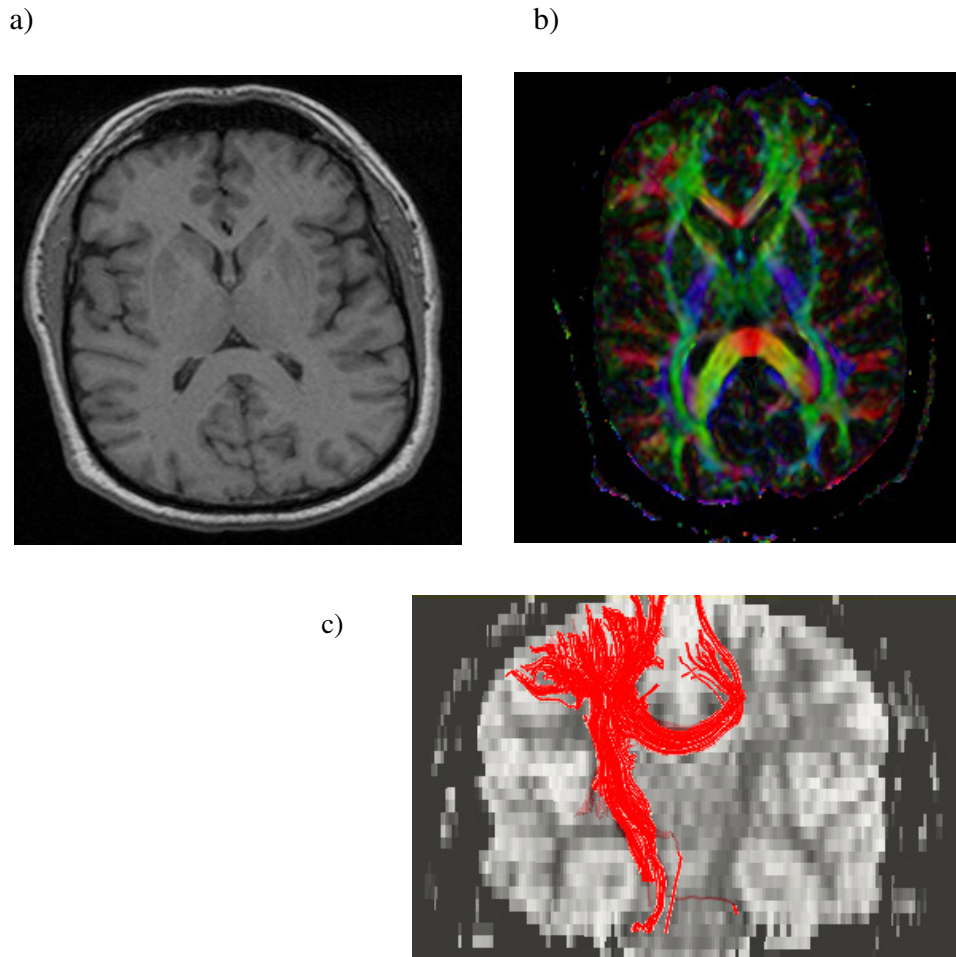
Brain MRI of one of our ALS subjects showing: a) T1 weighted image, b) DTI FA color map based on vector information (i) red color for left-right orientation, (ii) green for antero-posterior direction and (iii) blue for rostrocaudal orientation; and c) CST neuronal tracts reconstructed based on DTI tractography
